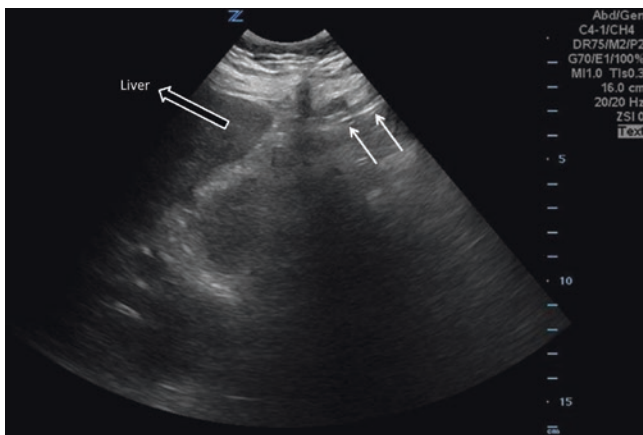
Ultrasound image of the normal peritoneum. The normal peritoneal stripe (*white arrow*) is identified by US as a single or double echogenic line posterior to the anterior abdominal wall. Normal air within the lumen of the gastrointestinal tract is recognizable by its association with bowel and moves with peristalsis in this scan of the right hypochondrium, performed with a convex probe. Image courtesy of Pimpa Limphan-udom
